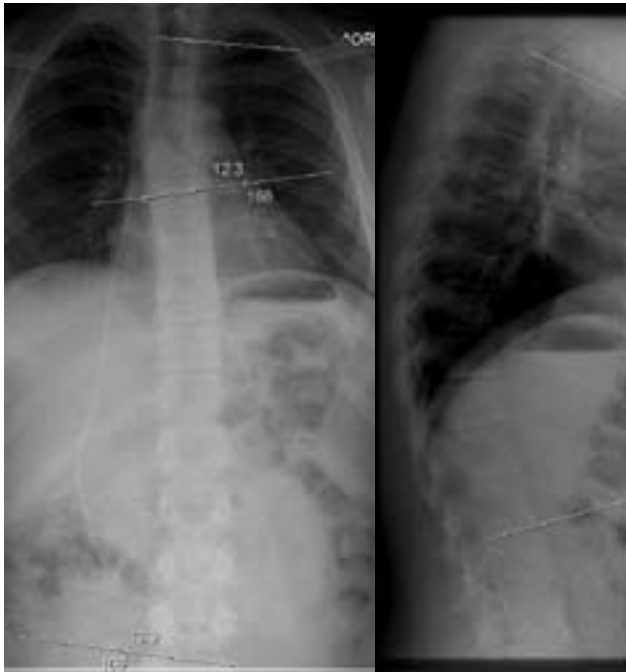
Radiographs of a 13-year-old boy showing a 12° upper right thoracic scoliosis and a 32° kyphosis.
